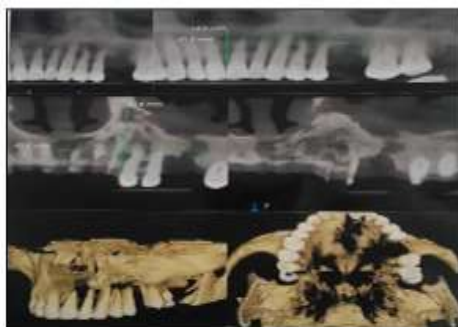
CBCT of Maxillary arch
